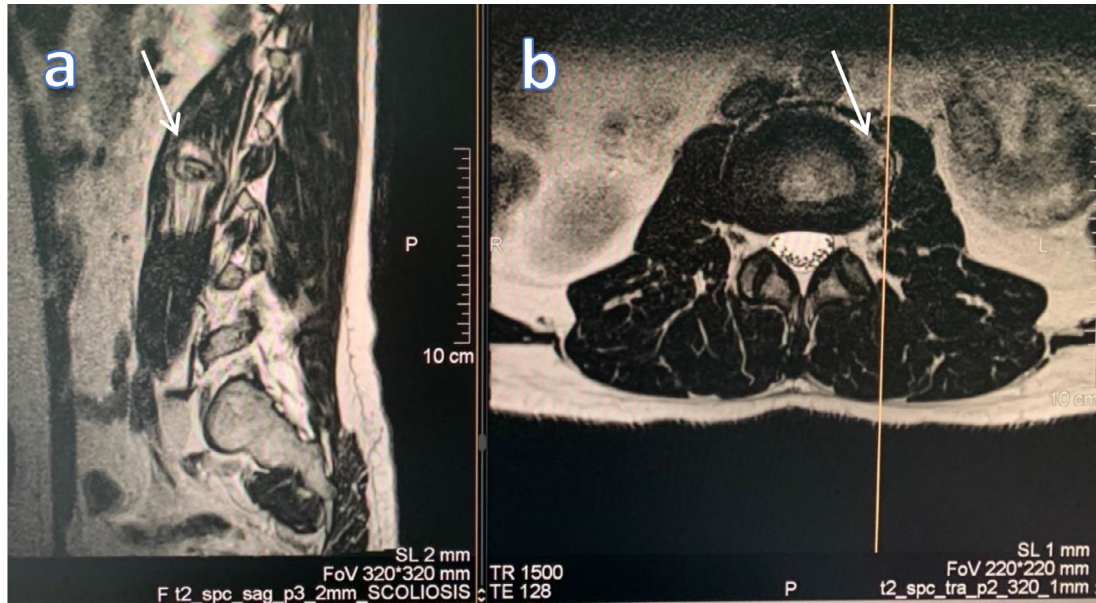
The coronal T2-weighted turbo spin echo scan shows significant protrusion of the herniated intervertebral disc at the L2-L3 level towards the left psoas muscle (shown by arrow)
